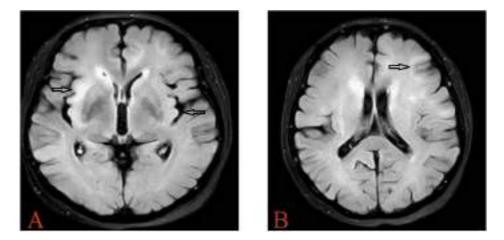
Figure I (A) MRI on FLAIR image shows well-demarcated bilateral hyperintensity (arrow) in insular. (B) MRI shows hyperintensity on T2-weighted and FLAIR images-(arrow) in the limbic system.
